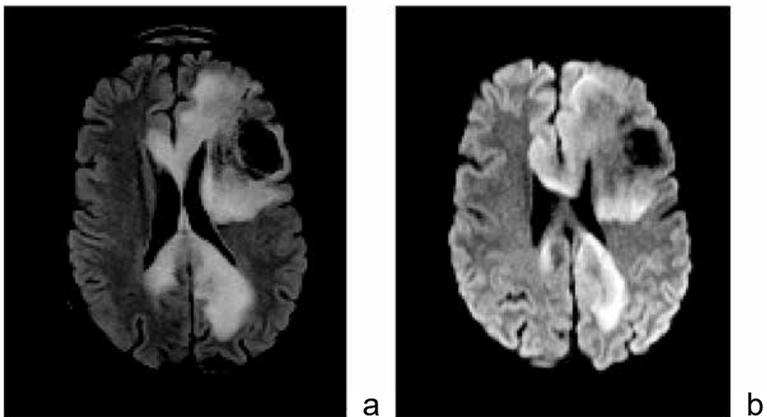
T2 FLAIR (a) and DWI (b) images in axial plane. Extensive areas of abnormal signals in the left cerebral hemisphere with corpus callosum involvement and peripheral bands of increased water molecule restriction in the extracellular space
